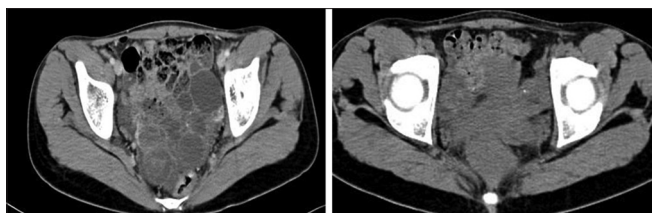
Magnetic resonance imaging showing the multicystic ovaries. Right hand side panel showing the effect of estrogen therapy
